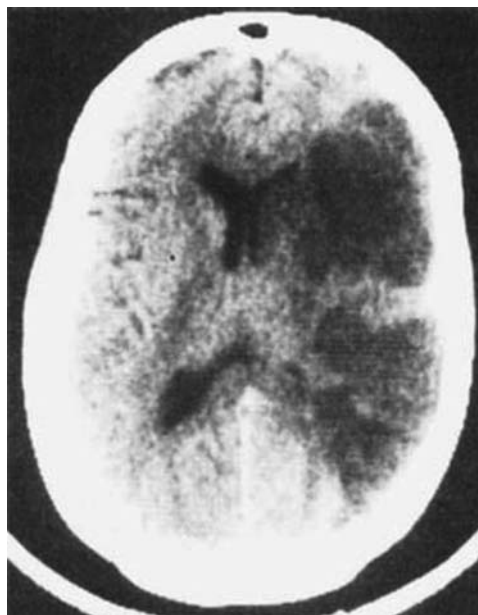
Images of the brain: 1990s. CT Scan image of one patient with left unilateral spatial neglect after right hemispheric damage: hypodense fronto-temporo-parietal area (Vallar et al., 1991, Fig. 2).
